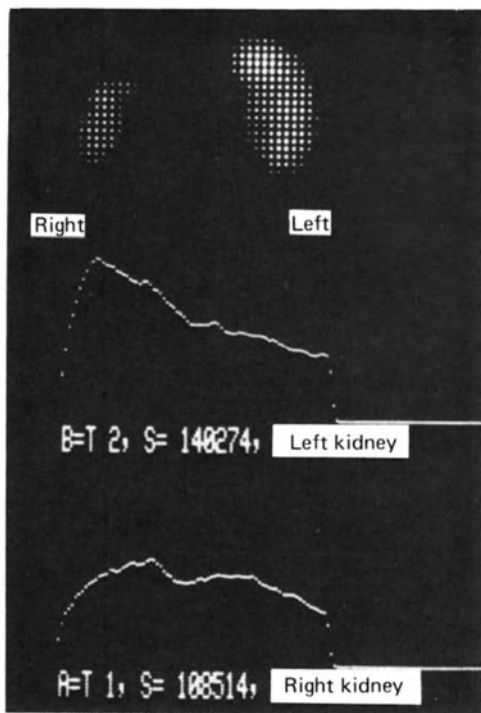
Renal phase scintigram of same patient as in Figure 10.
